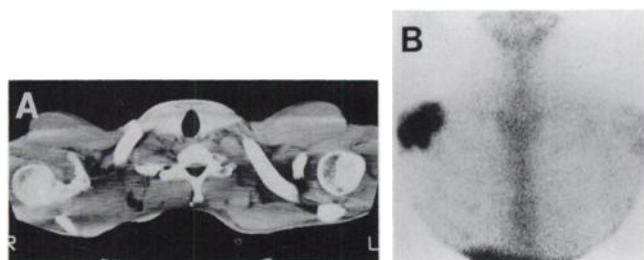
(A) The post-radiation therapy CT scan of a patient with synovial cell sarcoma of the right shoulder. The asymmetry, increased on the right, was felt to be consistent with changes due to radiation. (B) The concomitant anterior ^{67}Ga scan of the chest shows intense abnormal uptake in the right shoulder consistent with residual active tumor.
